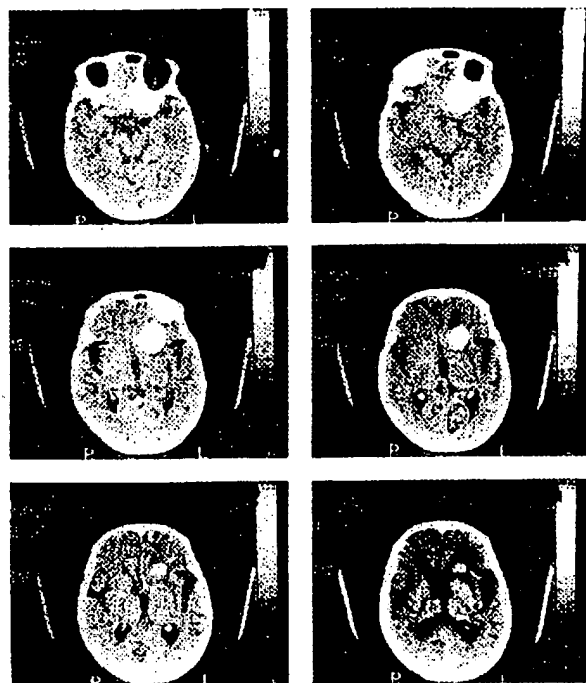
Calcifying process compatible with temporal meningioma. Brain CT scan:
